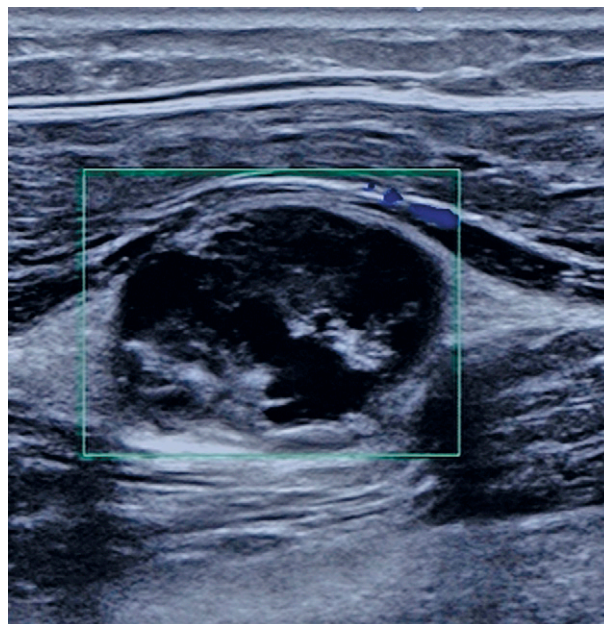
Ultrasound indicated a 37x21mm mass within the rectus femoris muscle of the right thigh, anechoic echoes and its internal echo is turbid. Sonograms show “bright rim” and “bright cap”.
